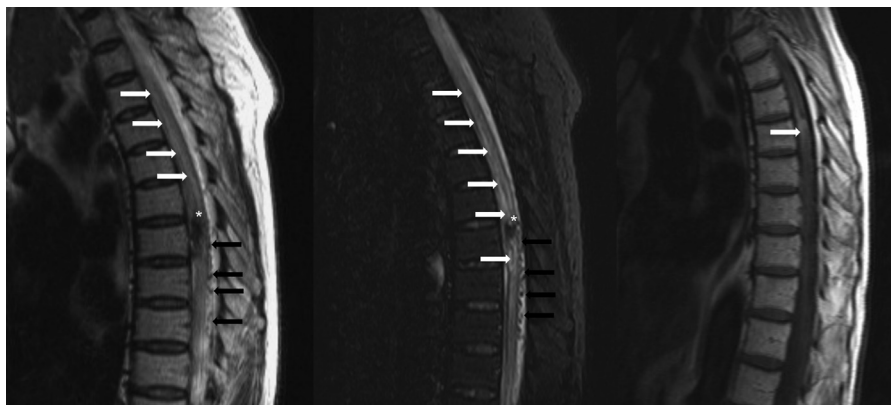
Preoperative magnetic resonance (MR) images. Sagittal T2 and T2*-weighted MR images of the spine (Left and Middle) show a focal area of low T2 signal at T7 (asterisks), with associated high T2 signal intensity within the spinal cord extending from C7 to T7 (white arrowheads). Flow voids are noted on the posterior aspect of the spinal canal (black arrowheads). T1-weighted MR image (Right) reveals high T1 intensity at T7 (white arrowhead), consistent with subacute hemorrhage.
